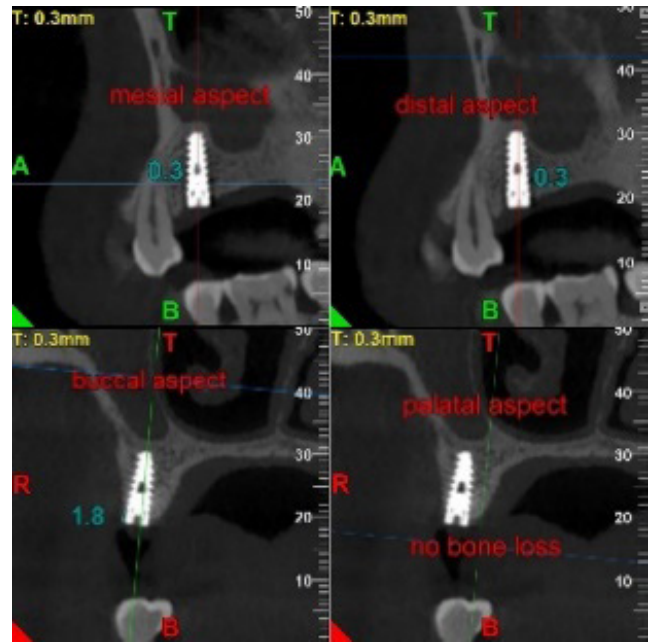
CBCT measurements in sagittal and coronal section.
